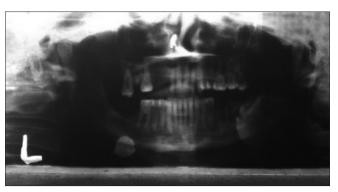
Orthopantomogram follow up 12 monthly (uneventful no recurrence)
